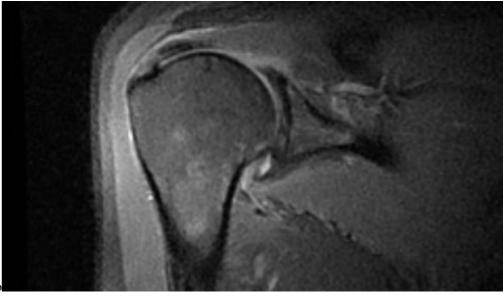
USG shows hypoechoic area along the bursal surface of the supraspinatous – s/o bursal surface tear Fig 4b. MRI coronal PDFS sequence shows corresponding hyper intensity along the bursal surface of the supraspinatous tendon
